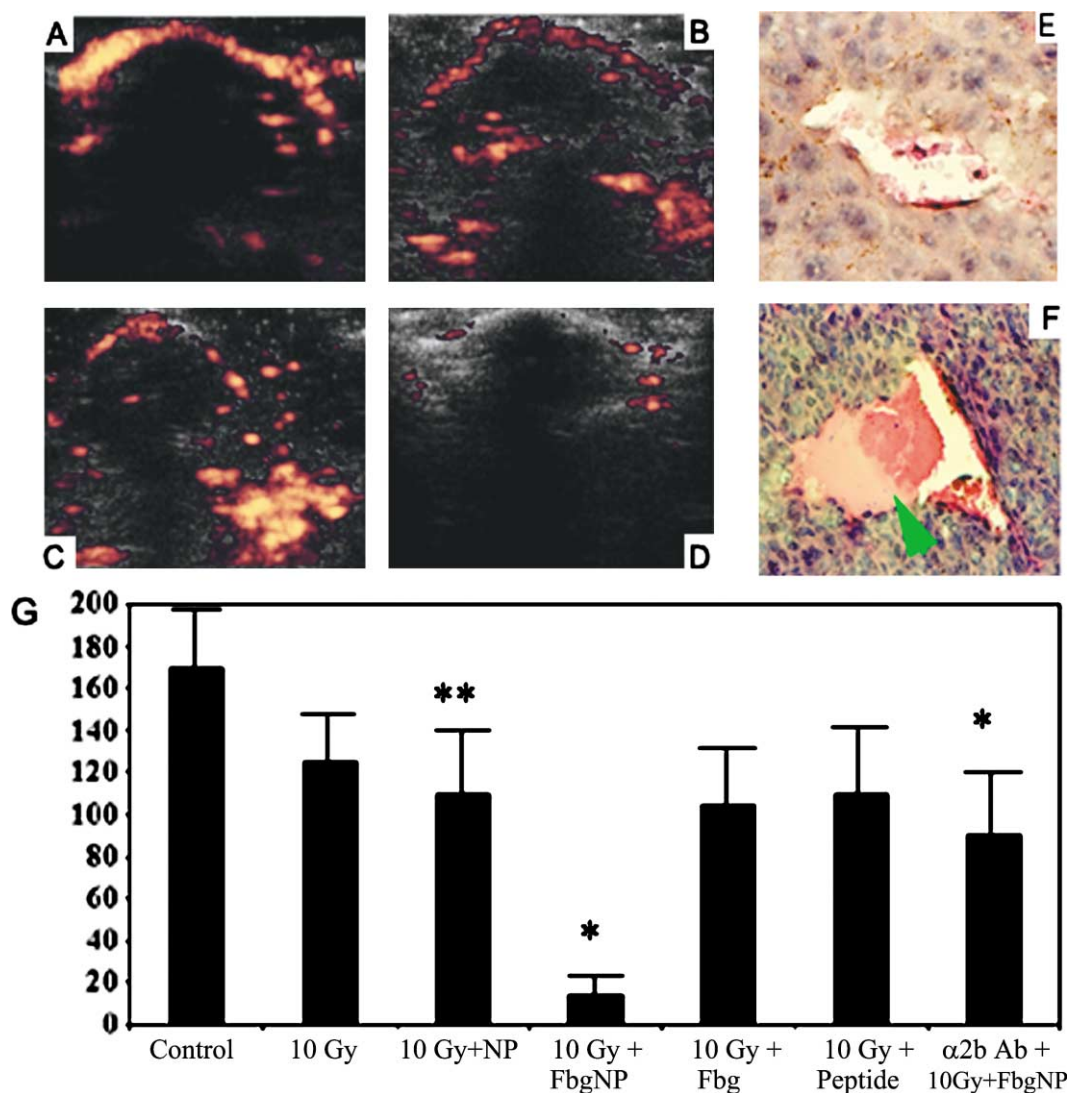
Tumor blood flow analysis by use of amputate modulated Doppler ultrasound
